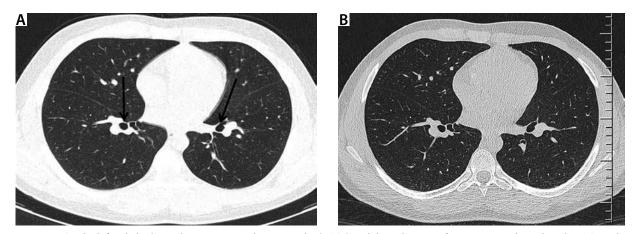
On the left side high-resolution computed tomography (HRCT) with bronchiectasis from 2011, on the right side HRCT without bronchiectasis from 2013
